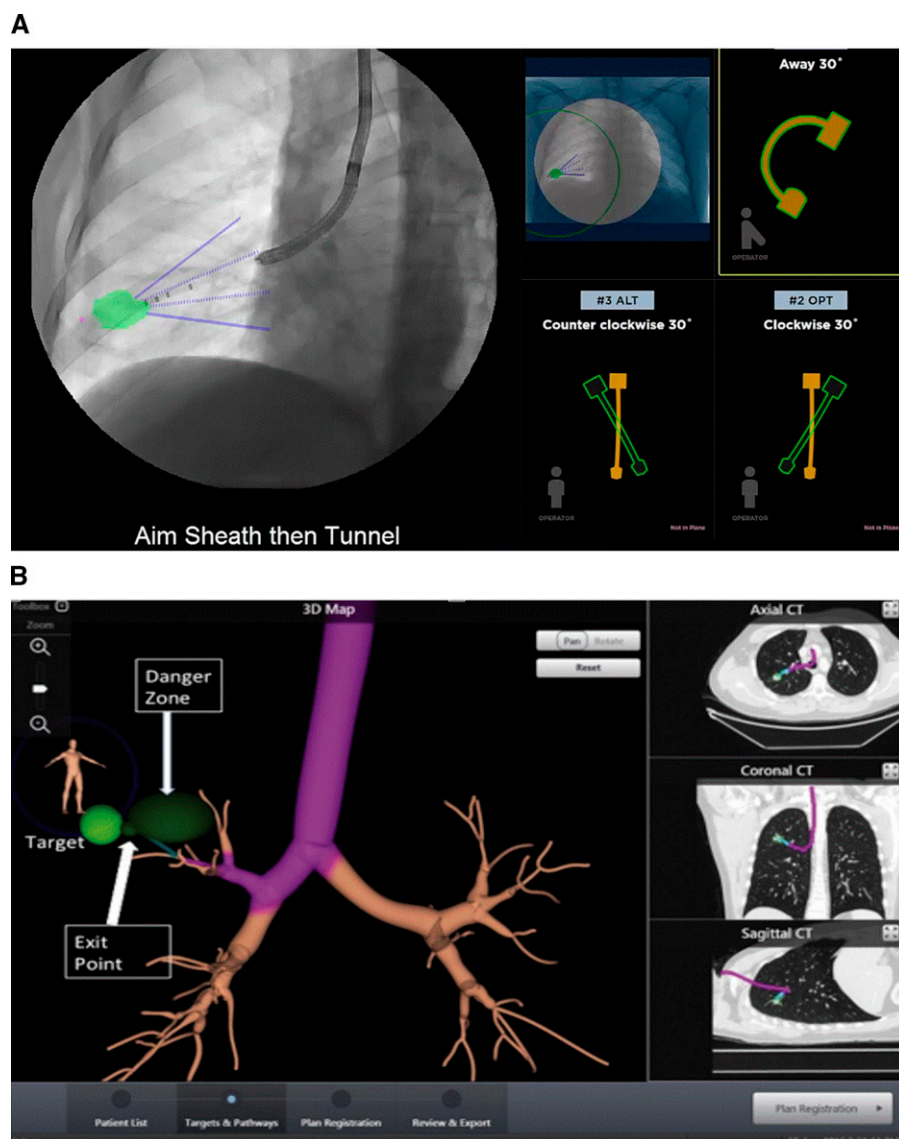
(A) View of transparenchymal nodule access on a solitary pulmonary nodule in the right lower lobe. Fused fluoroscopy is being used to create a fluoroscopically guided transparenchymal path to the superimposed target previously identified by planning high-resolution computed tomography. Purple dot represents virtual pleura. Multiple C-arm projections are used to confirm target location. (B) Three-dimensional (3D) map shows the danger zones and exit point, and the target lesion is demonstrated (23). CT=computed tomography.
